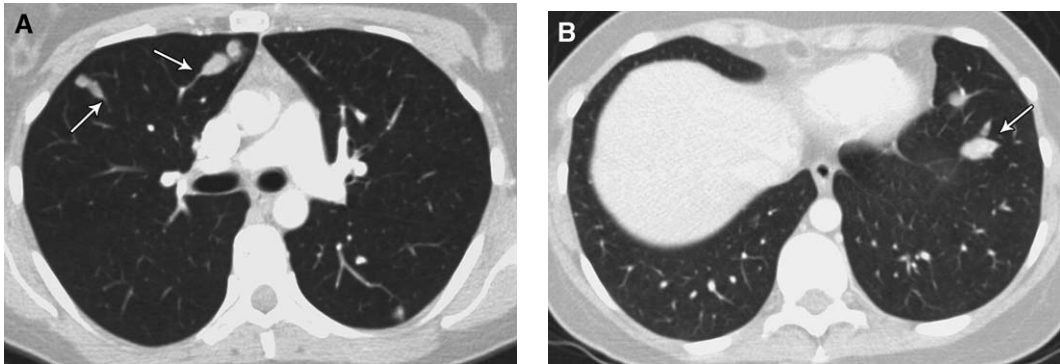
A 34-year-old woman with metastatic osteosarcoma. (A) CT scan of the lungs shows elongated nodules extending from normal-sized vessels consistent with tumor emboli (arrows). (B) CT scan of the lower lobes shows a branching tumor embolus in an intermediate-sized vessel (arrow).
